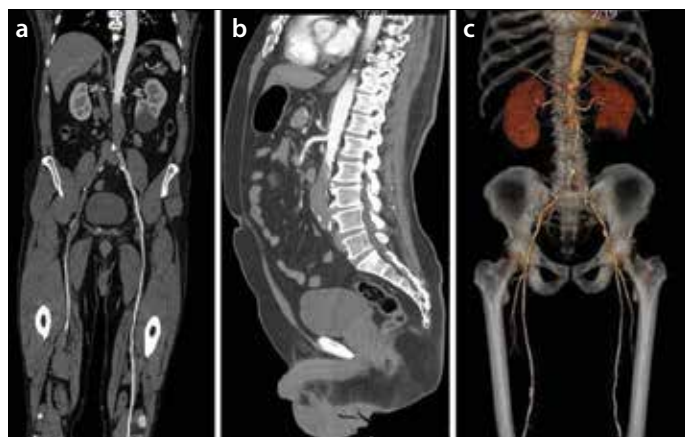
a-c. Coronal and sagittal view of contrast-enhanced computed tomography of the abdomen and (a, b) 3D-volume rendering images showing a filling defect of the infrarenal abdominal aorta and major iliac arteries (c)
